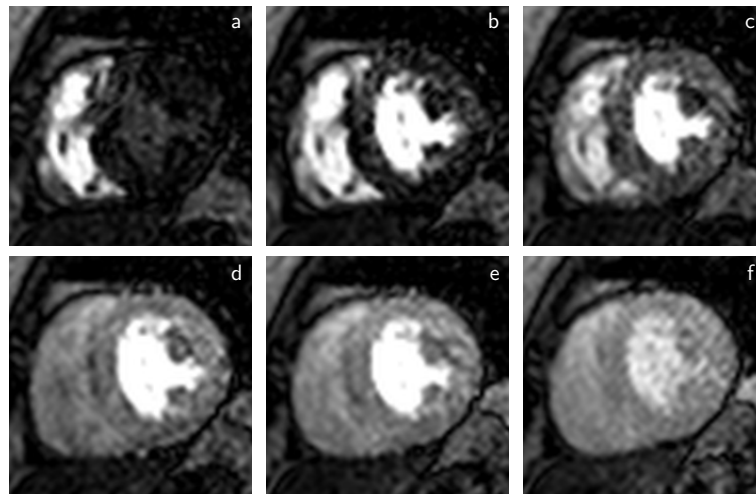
First-Pass Perfusion Cardiac Magnetic Resonance image sequence (from a to f): short-axis view of a normal subject during cardiac stress.
